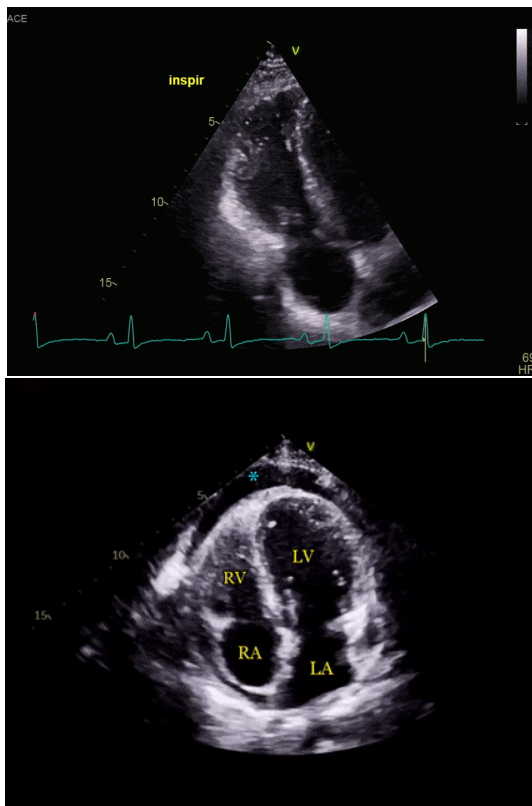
ECHOCARDIOGRAPHY IN PATIENTS WITH CONSTRICTIVE PERICARDITIS.
